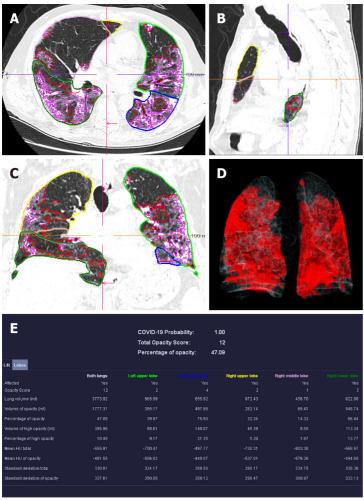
Computed tomography pneumonia analysis (automated lung opacity analysis). A-C: Multi-planar reconstruction views overlaid with delineations of the opacities and the lungs; D: Volume rendering image showing a quick overview of the spatial distribution of the opacities; E: Table with measurements demonstrating relative ("percentage of opacities") and absolute volume of opacities, mean and standard deviation of HU values between lung parenchyma and the detected opacities, separately segmented quantitative results per left and right lung and per lung lobe.
